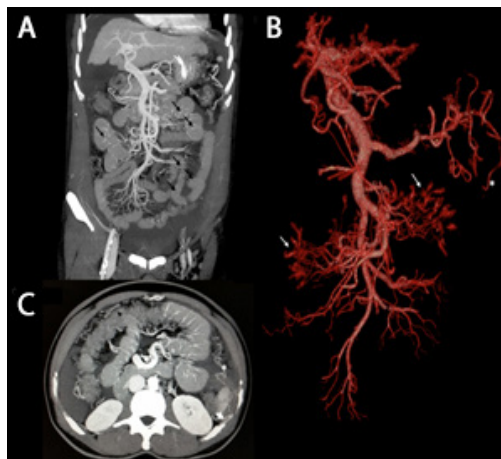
A,B,C: CT angiography of the abdomen showing shrunken dysmorphic liver with hyper dense free fluid and dependent clots in pelvis without active bleeding with distal duodenal and jejunal varices [black arrows (A, maximal intensity projection, CT coronal) and corresponding white arrows (B, CT curved planar reformation, 3-dimensional)] with associated multiple mesenteric (C, asterisk) and retroperitoneal ectopic varices with surrounding hematoma (C, white arrow head).
